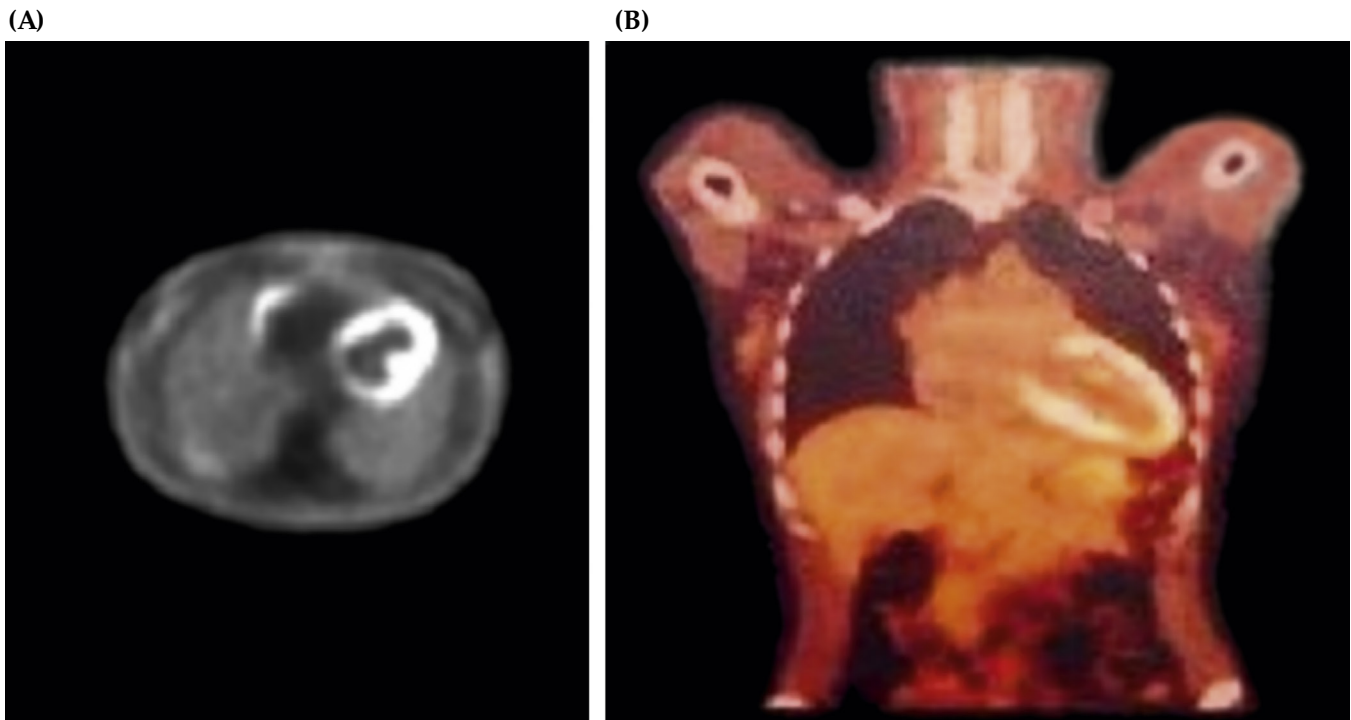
Pet CT image showing increased 18-fluorodeoxyglucose (FDG) uptake in the myocardium in a patient with acute rheumatic fever. (A) Transversal view; (B) Coronal view. Adapted from Nuclear Medicine Department, from Heart Institute (InCor), São Paulo, Brazil.
